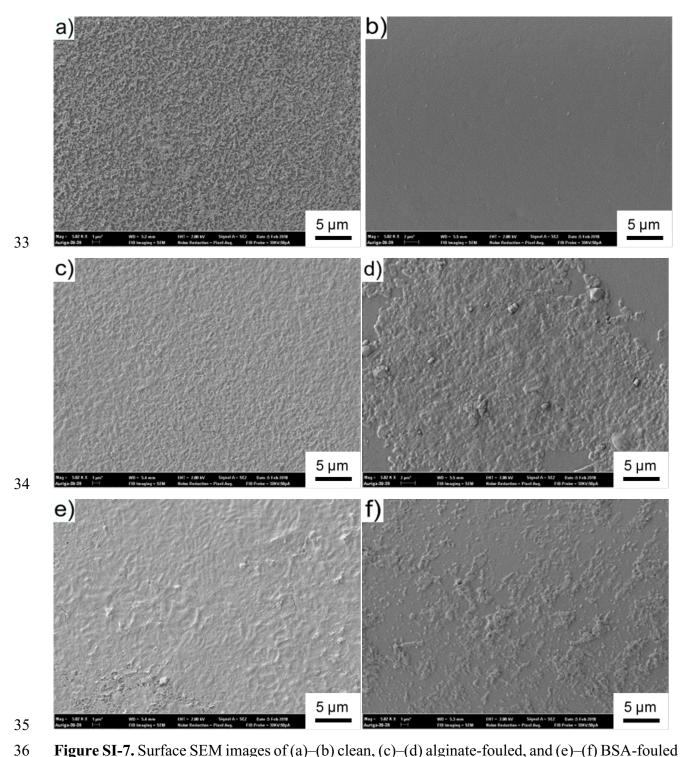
Figure SI-7. Surface SEM images of (a)–(b) clean, (c)–(d) alginate-fouled, and (e)–(f) BSA-fouled membranes (× 5K) for Aquaporin (a, c, and e) and CTA membranes (b, d, and f). Experimental conditions are introduced in Figure SI-5.
